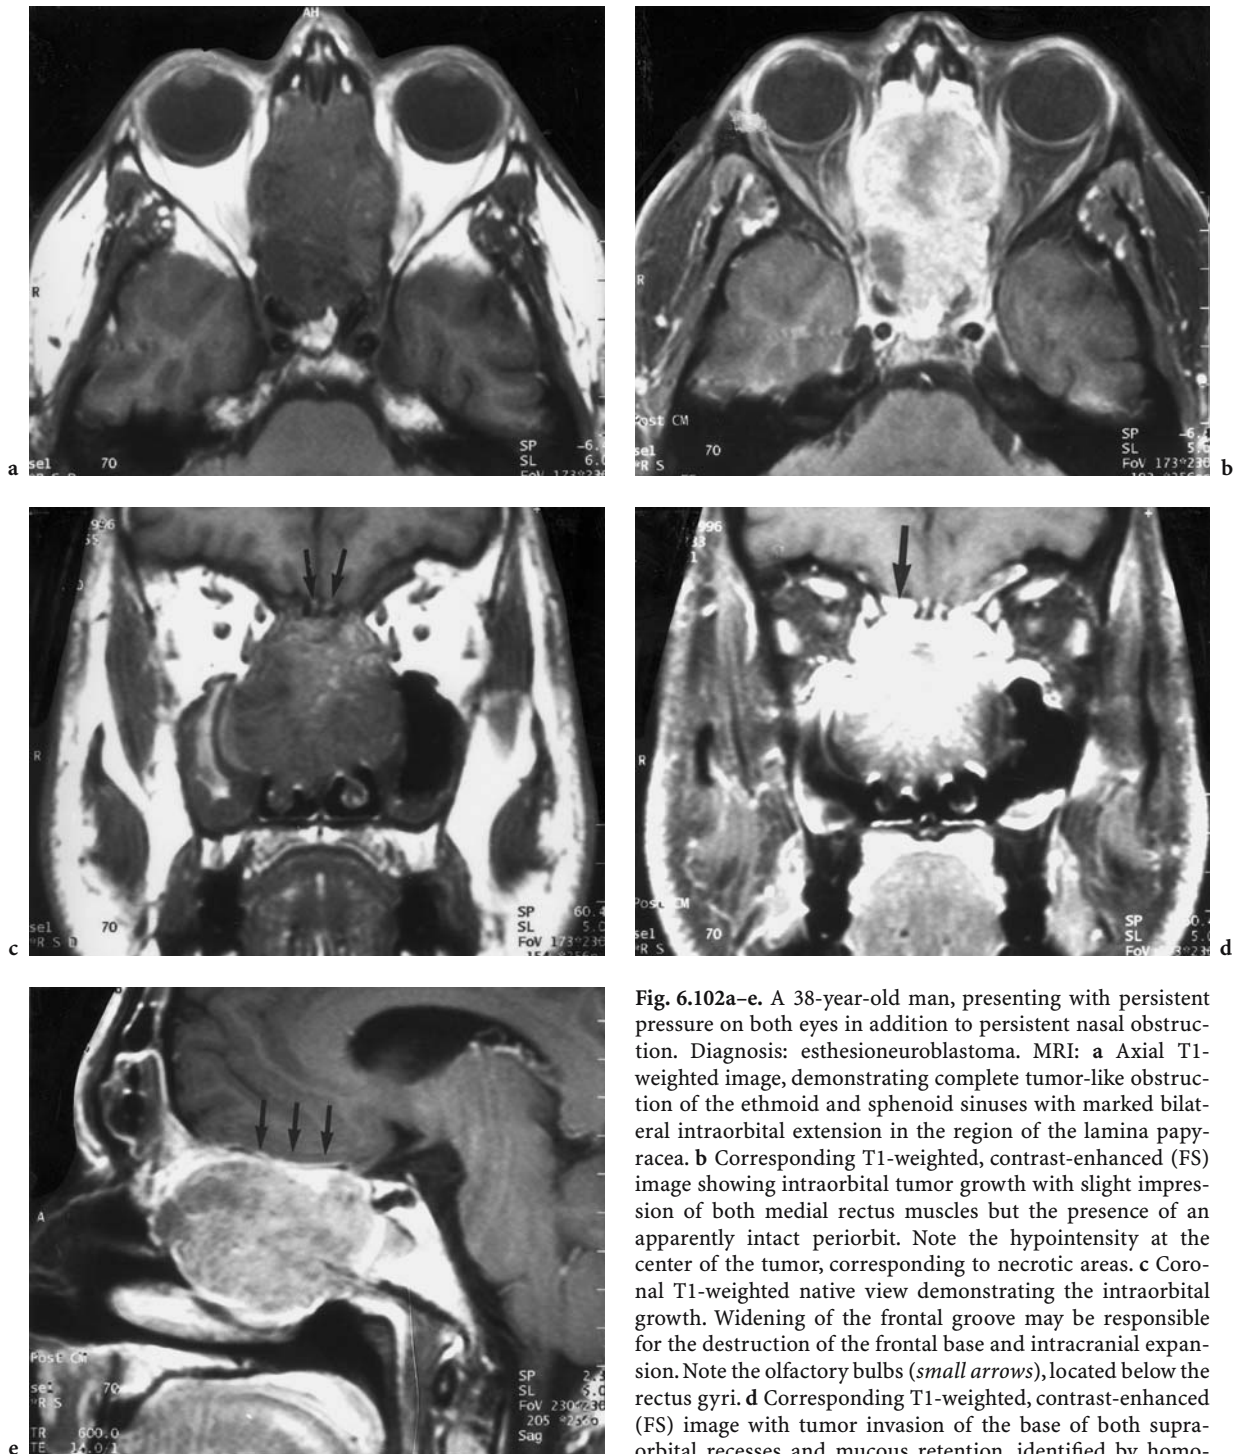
A 38-year-old man, presenting with persistent pressure on both eyes in addition to persistent nasal obstruction. Diagnosis: esthesioneuroblastoma. MRI: a Axial T1-weighted image, demonstrating complete tumor-like obstruction of the ethmoid and sphenoid sinuses with marked bilateral intraorbital extension in the region of the lamina papyracea. b Corresponding T1-weighted, contrast-enhanced (FS) image showing intraorbital tumor growth with slight impression of both medial rectus muscles but the presence of an apparently intact periorbit. Note the hypointensity at the center of the tumor, corresponding to necrotic areas. c Coronal T1-weighted native view demonstrating the intraorbital growth. Widening of the frontal groove may be responsible for the destruction of the frontal base and intracranial expansion. Note the olfactory bulbs (*small arrows*), located below the rectus gyri. d Corresponding T1-weighted, contrast-enhanced (FS) image with tumor invasion of the base of both supra-orbital recesses and mucous retention, identified by homogeneous signal intensity enhancement (*arrow*), no conclusive dural enhancement. e Sagittal paramedian, T1-weighted, contrast-enhanced view showing dural enhancement along the entire sphenoid plane (*small arrows*). Note the AP and cranio-caudal dimension of the tumor growth with destruction of the sphenoid bone and the bony palate
